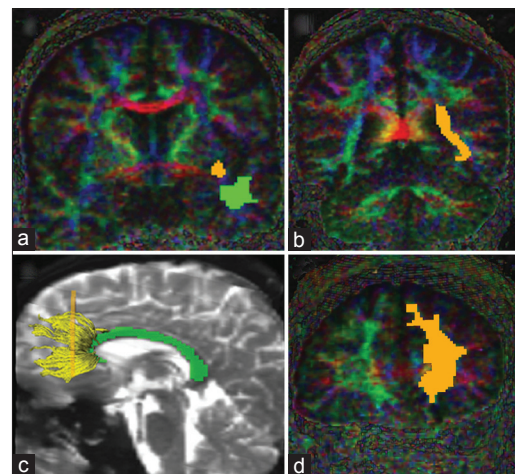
Locations of the ROIs for frontal lobe tracts on the directional maps (a-d) and tractography of the GCC (yellow) on b₀, an acquisition with similar T2-weighted images. A = ROI 1 (green) and ROI 2 (orange) for UNC. B = ROI 2 (orange) for IFO; ROI 1 is the same as ROI 2 for UNC; C and D = ROI 1 (green) and ROI 2 (orange) for GCC. ARC = arcuate fasciculus; GCC = genu of corpus callosum; IFO = inferior fronto occipital fasciculus; ROI = region of interest; UNC = uncinata fasciculus
